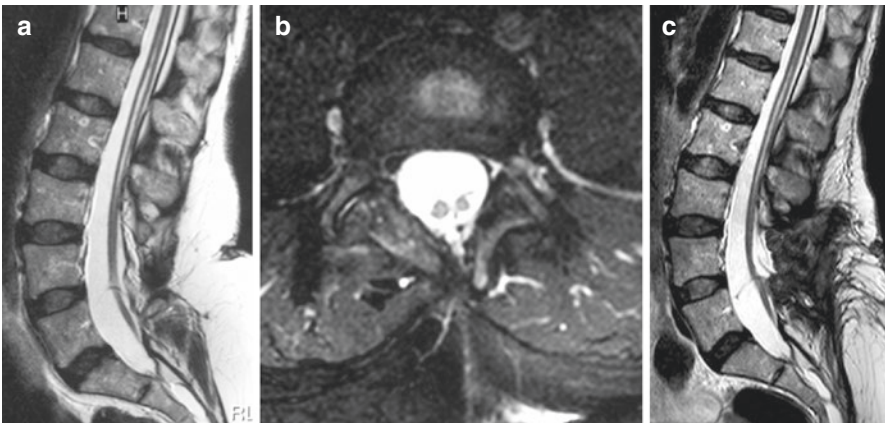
(a) This T2-weighted image of a 53-year-old woman demonstrates the conus position at S1 and a small syrinx in the lower part of the cord, which exerts no space-occupying effect. (b) The axial scan at L4/5 shows a split cord malformation type 2 with a fibrous band splitting and fixing the cord at this level. Extradurally, this band was connected to a dermal sinus. Surgery required section of the filum terminale below S1 and untethering at L4/5. (c) The postoperative T2-weighted image shows no significant change of the syrinx despite complete untethering of the cord
